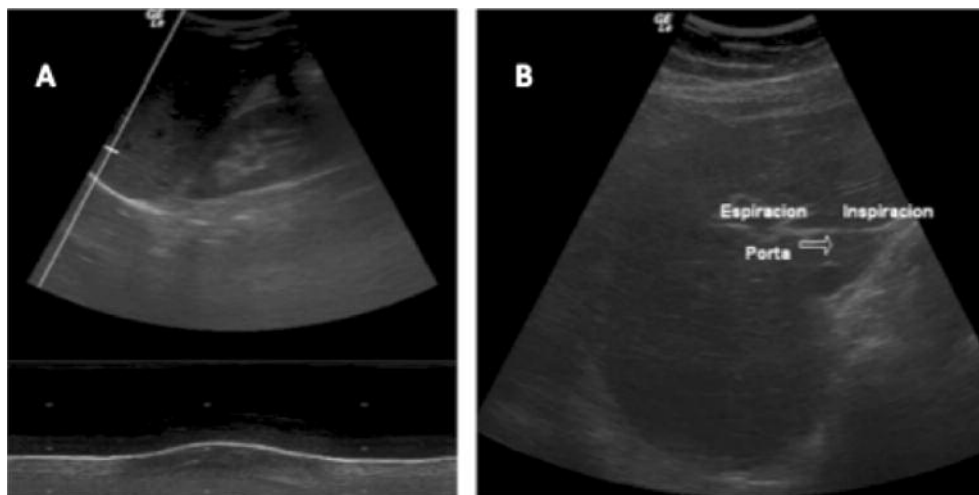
Ultrasound images of the two methods of measuring diaphragm motion. A) Direct diaphragmatic motion: displacement of the diaphragmatic dome in the right anterior axillary line parallel to the intercostal space. Mode B and mode M. B) Motion of the portal diaphragm: displacement of the left branch of the portal vein between inspiration and expiration in the right subcostal region. Mode B.
